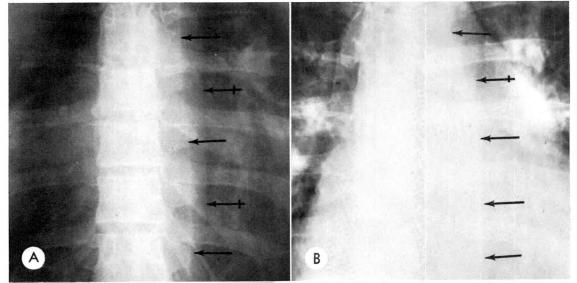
Case II. (A) A supine anteroposterior overexposed grid roentgenogram of December 28, 1964, demonstrating a normal relationship of the left paravertebral line ( $\leftarrow$ ) and the aorta ( $\leftrightarrow$ ). (B) A posteroanterior erect roentgenogram of January 20, 1965 shows a left midlung field infiltrate and fluid in the left costophrenic sulcus. The left paravertebral line was only faintly demonstrated on the original roentgenogram. The aorta ( $\leftrightarrow$ ) is in normal position. (C) A supine anteroposterior overpenetrated grid roentgenogram of January 20, 1965 demonstrating widening of the left paravertebral line ( $\leftarrow$ ) in relationship to the aortic shadow ( $\leftrightarrow$ ). (D) A supine anteroposterior overexposed grid roentgenogram of January 29, 1965 demonstrating return of the left paravertebral line ( $\leftarrow$ ) to its normal position in relationship to the aorta ( $\leftrightarrow$ ). The patient was asymptomatic.
